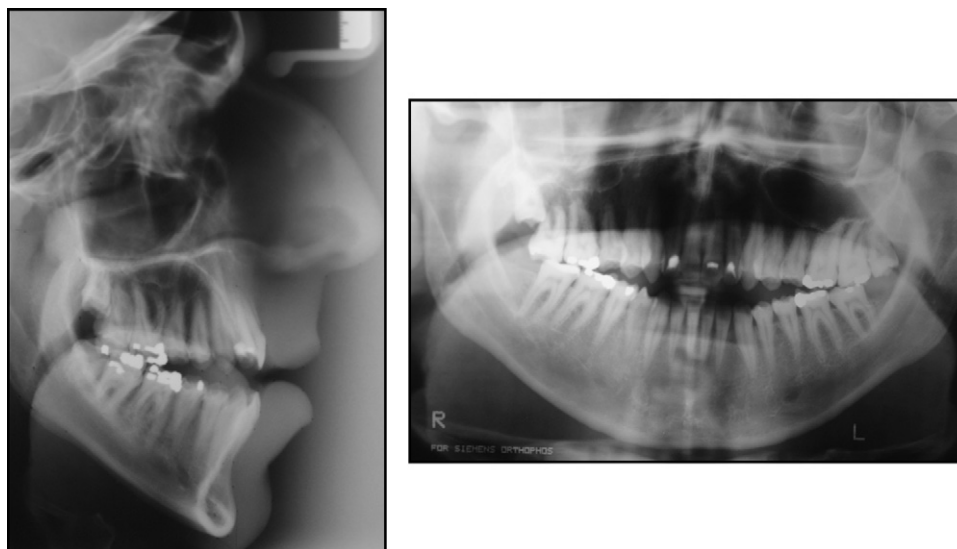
Pretreatment cephalometric radiograph and pantomograph.
